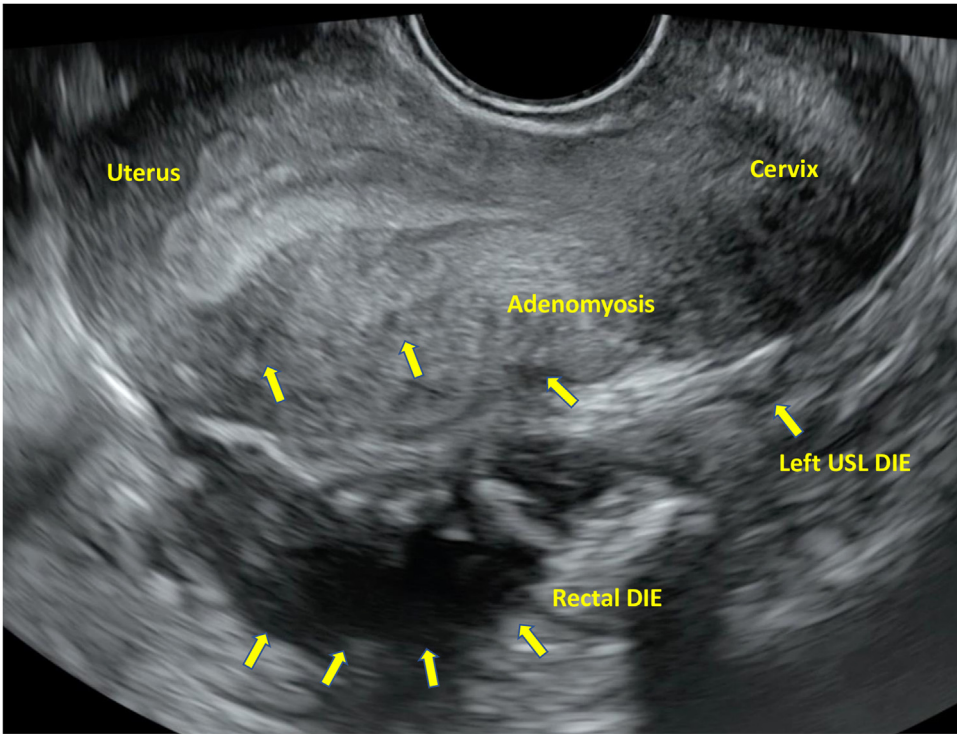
Transvaginal ultrasonographic appearance of adenomyosis associated with deep infiltrating endometriosis in one patient with Crohn's Disease. Gray-scale longitudinal section showing the uterus with adenomyosis with hyperechoic islands (yellow arrows in the uterus). Posterior to the uterus, a hypoechoic endometriotic fibrotic nodule infiltrating the muscular layer of the anterior rectal wall and the left utero-sacral ligament is detected (yellow arrows).
